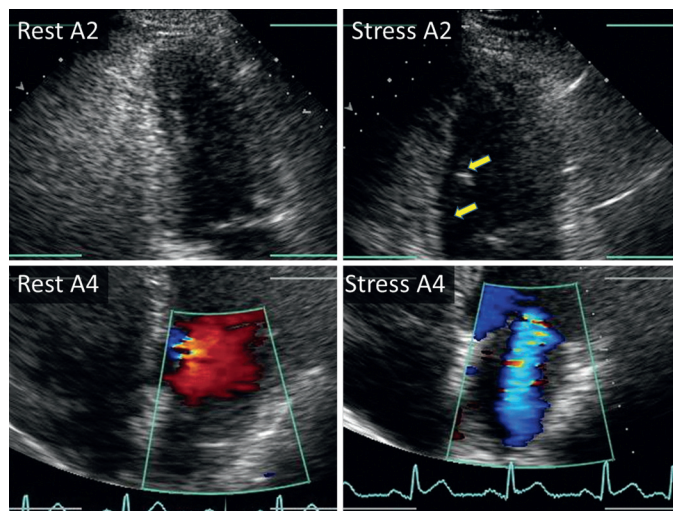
Stress echocardiography with evidence of ischemia in the RCA territory and acute ischemic MR. Resting and stress echocardiograms in the apical two-chamber (A2) and apical four-chamber (A4) views with color Doppler reveal new stress-induced inferior hypokinesis (arrows) in the area containing the posteromedial papillary muscle and increased MR. This patient was found to have 90% stenoses of the RCA and left circumflex artery on cardiac catheterization.
